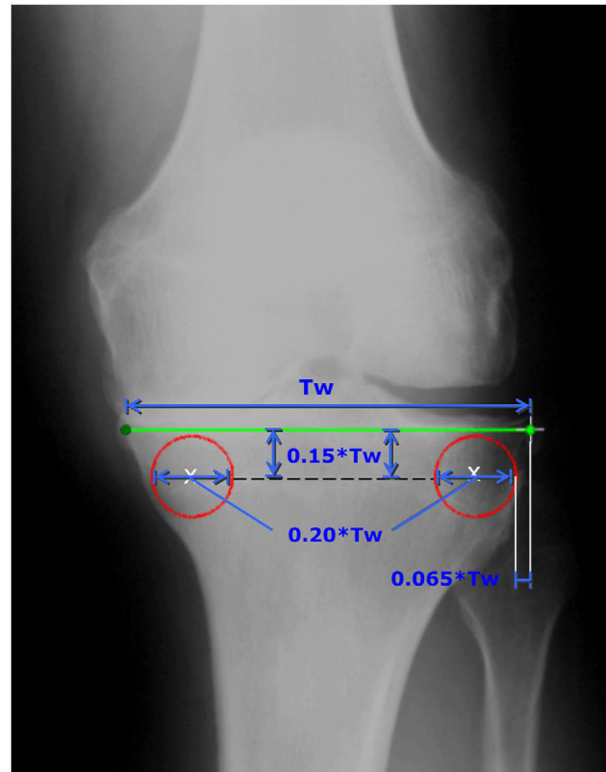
Placement of locator-rule endpoints on anatomic landmarks in knee radiograph for identification of subchondral ROIs. Endpoints of a locator rule (Tw) were positioned on the non-osteophytic tibial borders just inferior to the tibial plateau cortical plates (bone–cartilage interface). Constructed ROIs were placed at certain distances as a function of Tw , away from landmarks.
